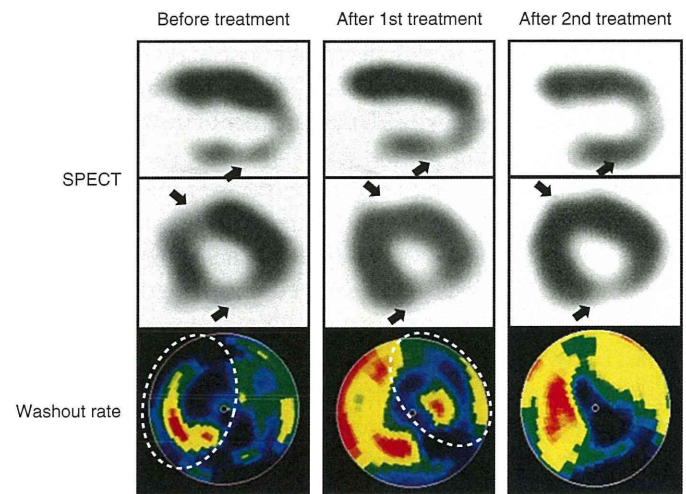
Effects of extracorporeal cardiac shock wave (SW) therapy on myocardial perfusion in patients with severe angina pectoris. Dipyridamole stress thallium-201 single photon emission computed tomography (SPECT) imaging and polar map in a patient with severe three-vessel coronary artery disease before and after SW therapy. The results clearly demonstrated that SW therapy ameliorated myocardial perfusion only where SW was applied; in the anteroseptal wall after the first treatment and in the lateral wall after the second treatment (arrows) in a step-wise manner after the staged SW therapy. The areas treated with SW therapy are indicated with dotted lines. From Fukumoto et al.,^[23] with permission.
